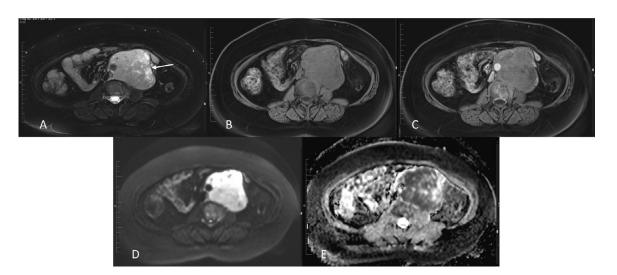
Multiaxial, multisequential pre- and postgadolinium MRI images of the abdomen and pelvis were obtained, which re-demonstrated the left para-aortic retroperitoneal mass. It appeared to be irregularly shaped with sharp margins, heterogeneous on both T2 (A) and T1 (B) with enhancement in T1 postcontrast (C), showing significant restriction diffusion in DWI (D) and ADC (E) Map sequences.
